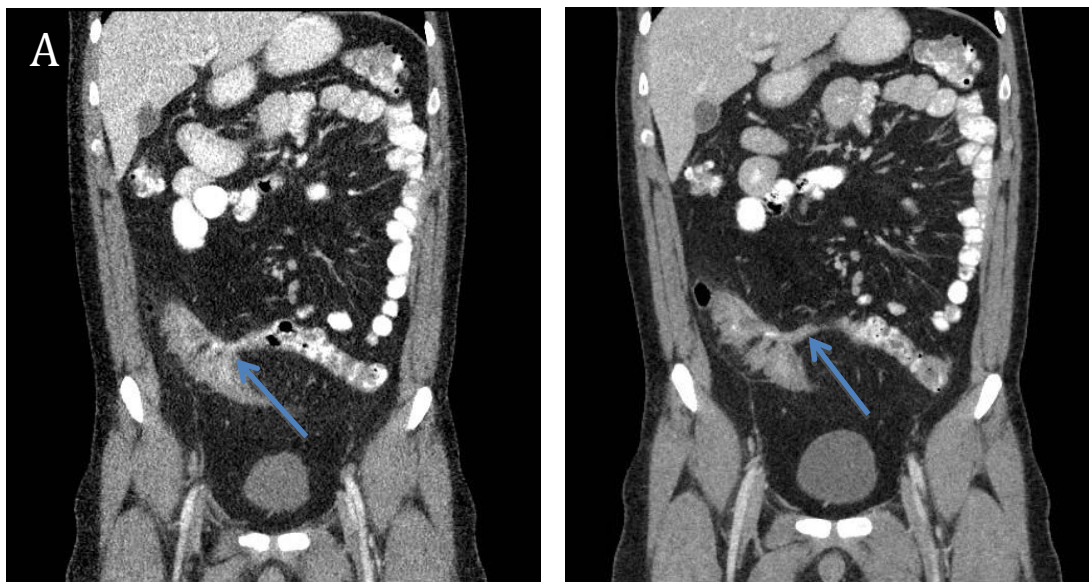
Modified (A) and conventional (B) dose coronal CT reconstructions of the abdomen and pelvis with blue arrows demonstrating an enterocolic fistula in a 31 year old man with a BMI of 26.9kg/m². The effective doses of the modified and conventional dose acquisitions are 1.6mSv and 6.5mSv, respectively.
